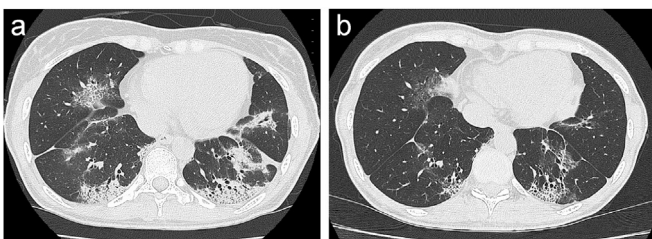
High-resolution computed tomography scans. Peribronchial consolidations, subpleural reticular shadows, and ground glass opacities were seen in both lower lobes (a). These findings were reduced over 11 month of the observation period (b).
